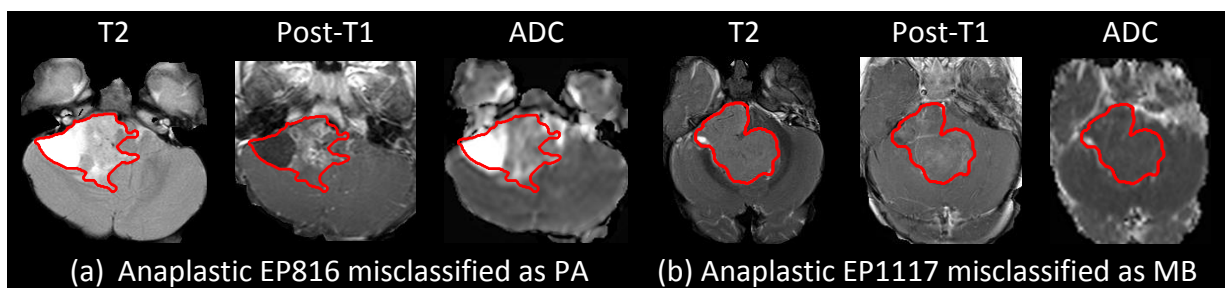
Four cases misclassified by the combined multimodal MRI based TA approach.
